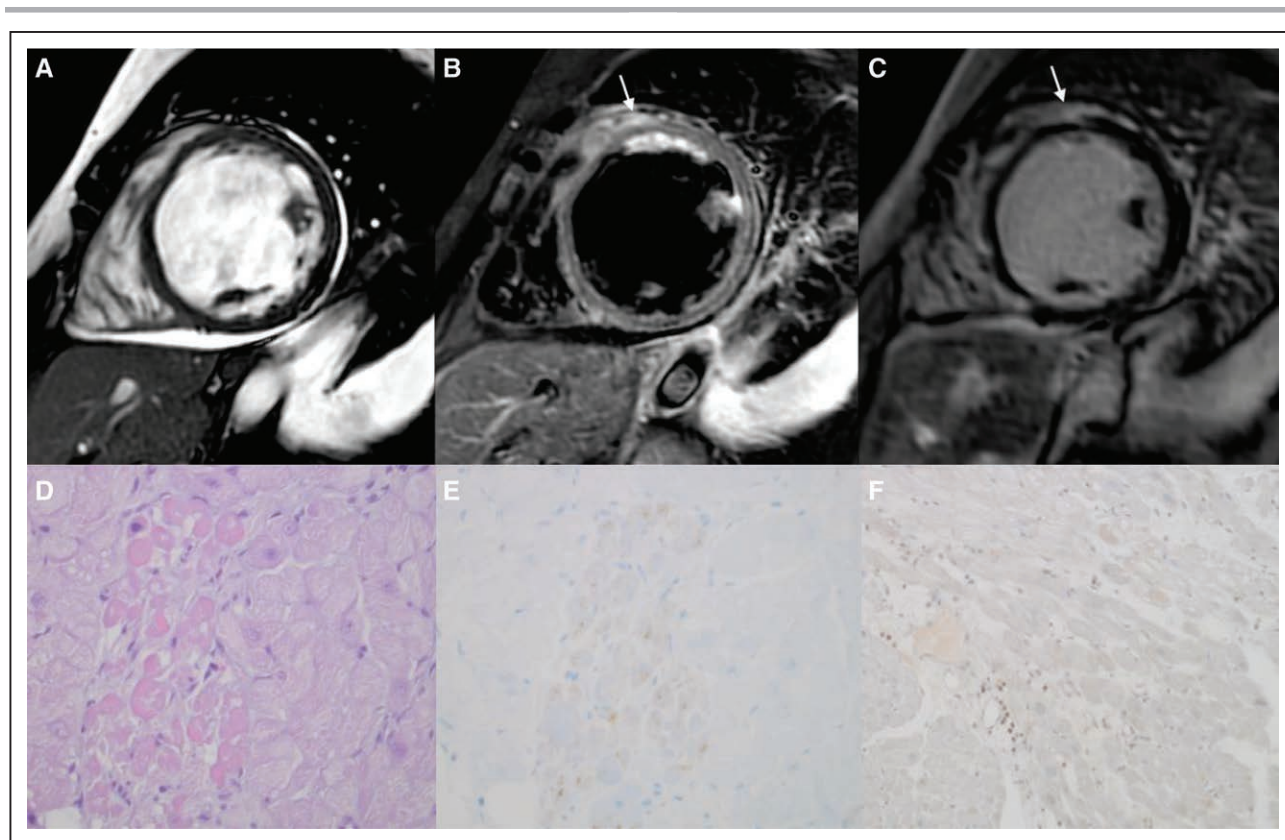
Cardiac magnetic resonance images (MRIs) of the patient with a likely pathogenic variant in RBM20.
